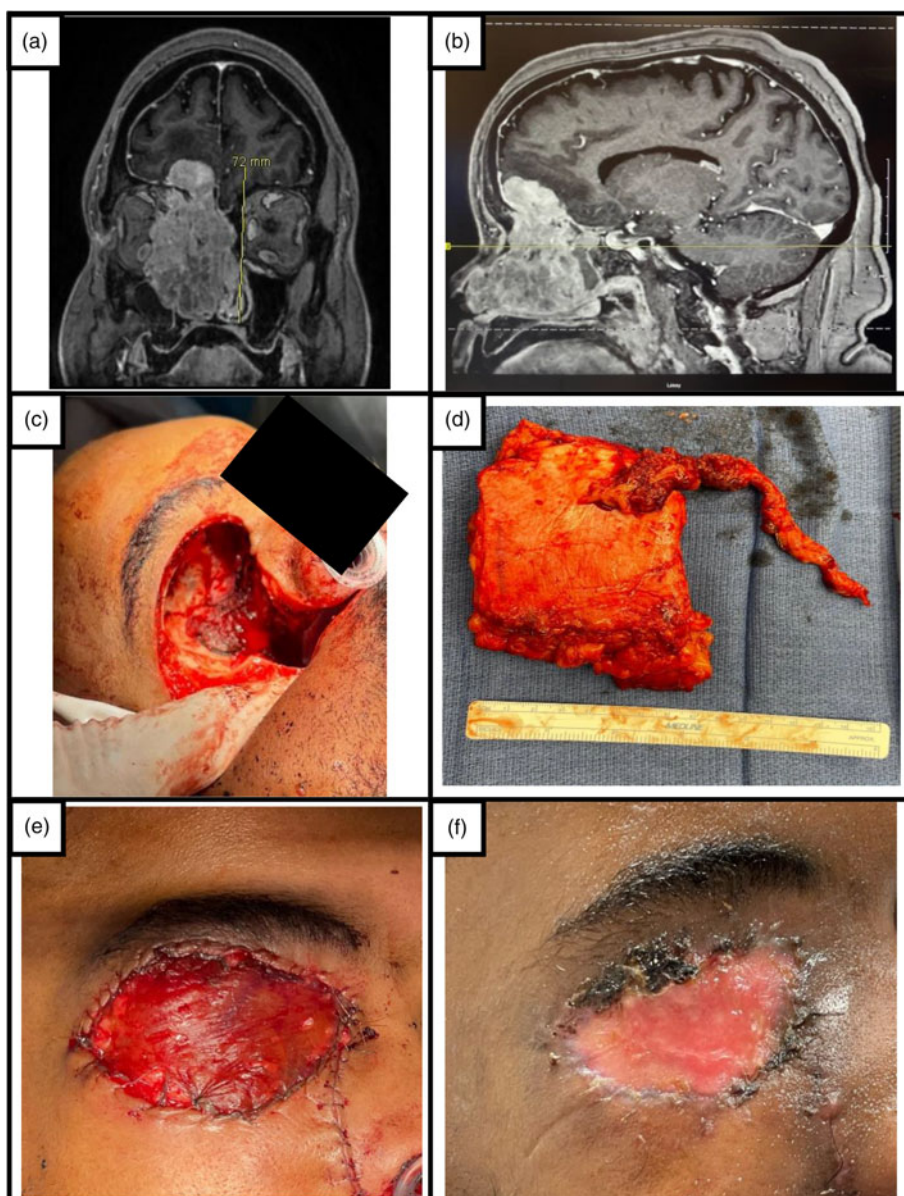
Adipofascial anterolateral thigh (AF-ALT) reconstruction of anterior skull base with orbital exenteration defect (case 6). (A) Coronal and (B) sagittal MRI images depicting the tumor. (C) Defect site post-resection and duraplasty. (D) Harvested AF-ALT free flap. (E) Defect site post-flap placement with overlying split thickness skin graft. (F) Defect site at follow-up 40 days post-operatively.
